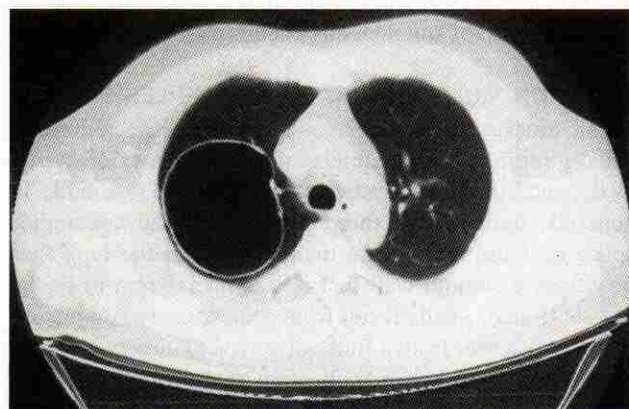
Computed tomogram shows a large smooth thin-walled cyst in the right upper lobe—a bronchogenic cyst.
